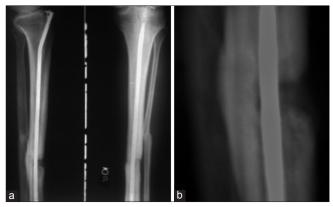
X-ray after insertion of antibiotic-mixed polymethyl methacrylate bone cement-wrapped nail when 3 cortices union is complete, (a) anteroposterior and lateral views, (b) focussed view
